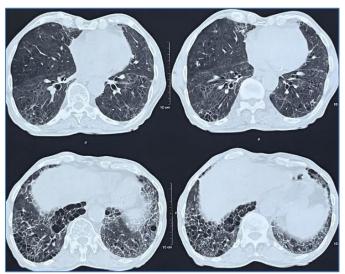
HRCT thorax showing bilateral peripheral subpleural tractional bronchiectasis and honeycombing
